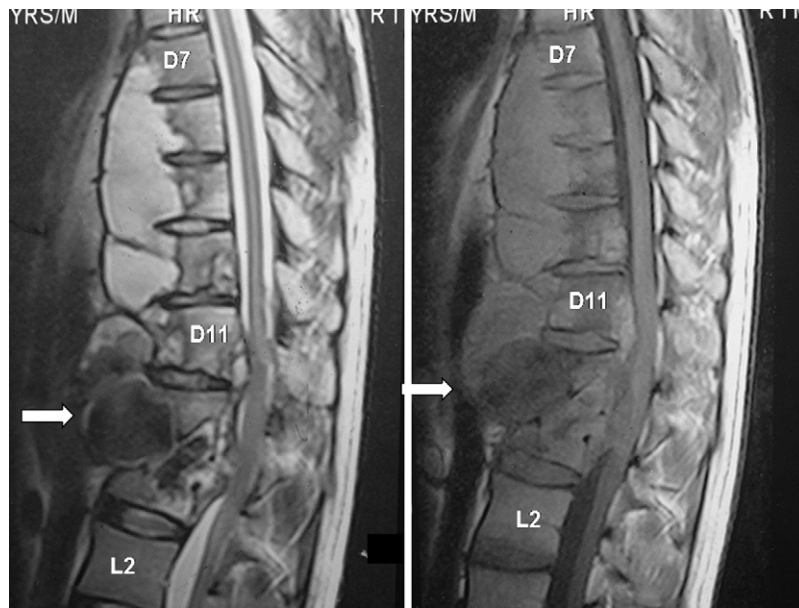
Magnetic resonance imaging (sagittal sections, T2-weighted imaging and T1-weighted imaging) showing a signal void lesion in front of D11–L1 vertebral bodies in both films. Multiple outpouchings suggest breach of intima and hence the formation of a pseudoaneurysm.
